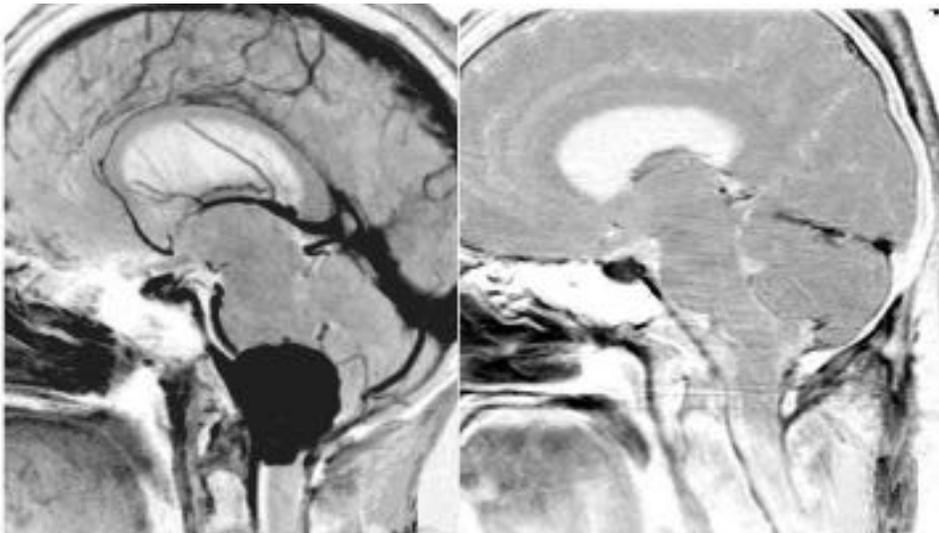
Magnetic resonance imaging (MRI) of a large ventral foramen magnum meningioma totally removed through a transcondylar approach. (A) Preoperative sagittal enhanced MRI. (B) Postoperative sagittal MRI demonstrating complete removal.
